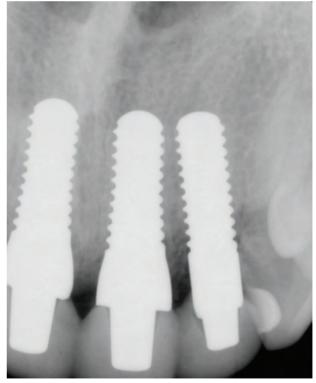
Healed implants radiograph
